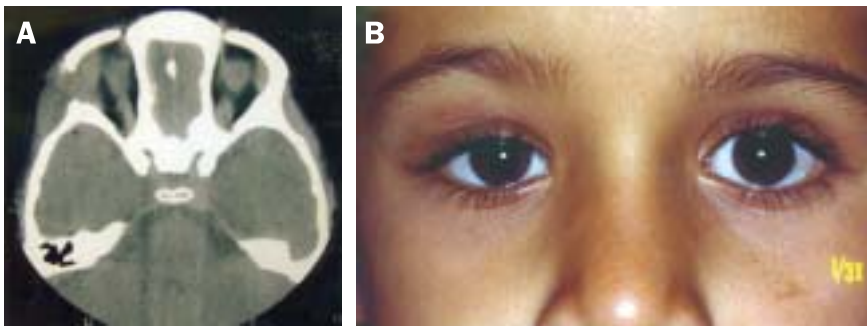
Five year old girl with Langerhans' cell histiocytosis. [A] Axial computed tomography scan showing a destructive soft tissue mass in the supero-lateral aspect of the right orbit, which eroded the fronto-zygomatic suture. [B] External appearance of the same patient showing minimal erythema and swelling of right upper lid.
